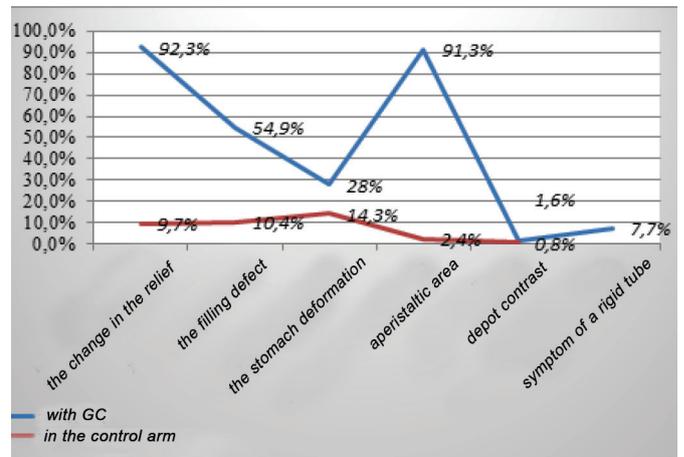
Distribution of X-ray symptoms at gastric cancer and in the control arm
